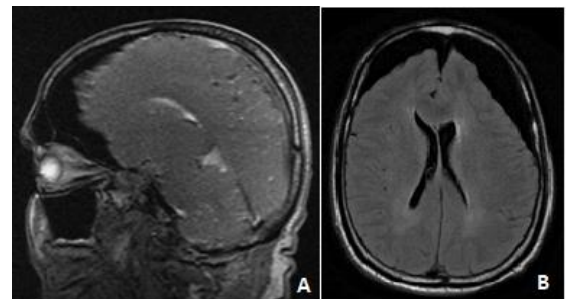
MRI Brain showing bilateral fronto-parietal pneumocephalus with mass effect on the lateral ventricles and midline shift.
